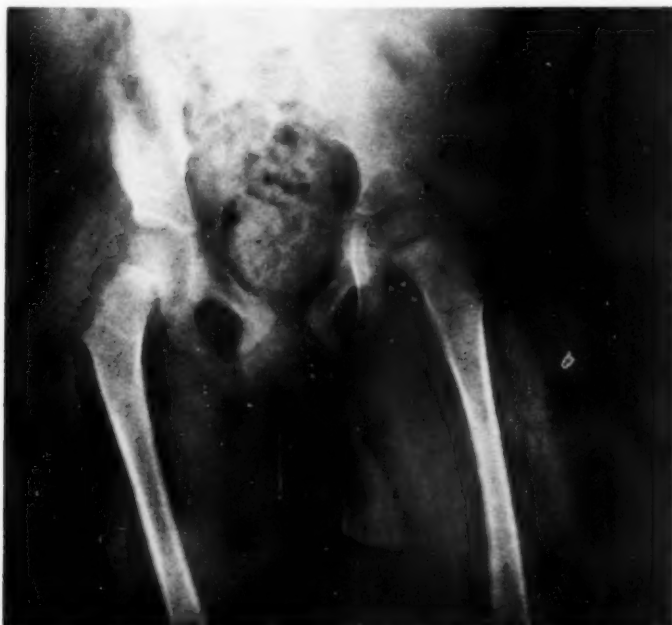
Anteroposterior roentgenogram of the hips and upper thighs in Case 1, clearly outlining the muscle bundle atrophy and nicely demonstrating the osteoporosis.
